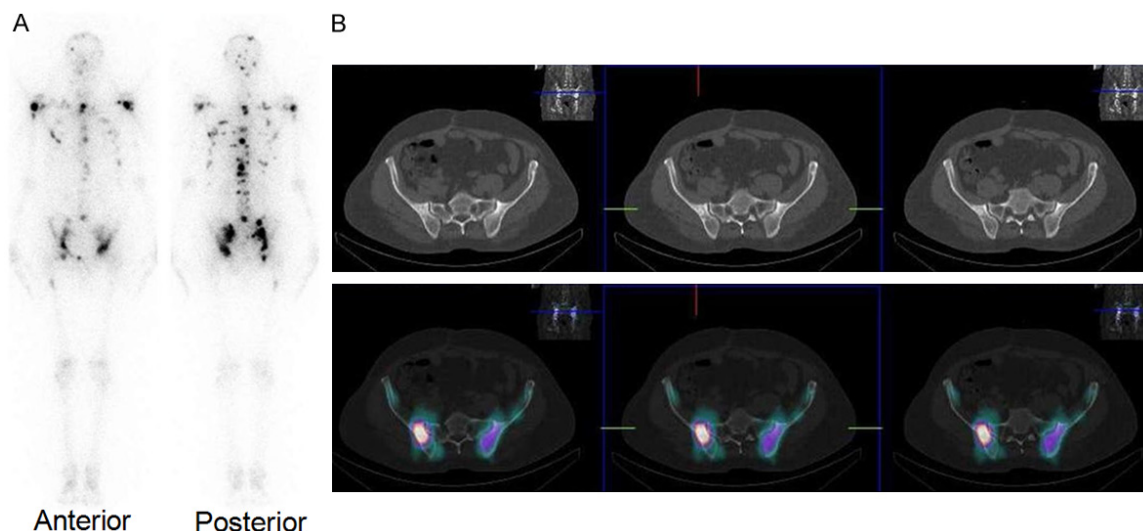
A 55-year-old male diagnosed with prostatic adenocarcinoma was administered with ^{177}Lu -DOTA^{zo1}. (A) Post-therapy WBS 24 h post-administration showed uptake in multiple skeletal sites, (B) Post-therapy SPECT/CT showed uptake in the pelvic bone metastases. Adapted from Ref [157].
